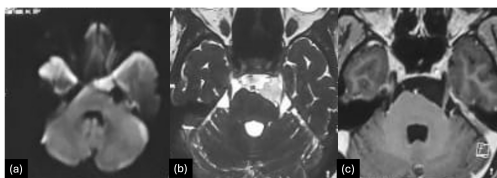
(a) Axial diffusion-weighted imaging (DWI) image shows a lesion in the Pre-pontine cistern showing diffusion restriction. (b) Axial FIESTA image shows the lesion has a T2 hyperintense signal and is displacing and compressing the cisternal segment of the left trigeminal nerve. (c) Post-contrast axial T1W image shows the lesion does not show any contrast enhancement. Imaging features suggestive of an epidermoid cyst in the prepontine cistern.
